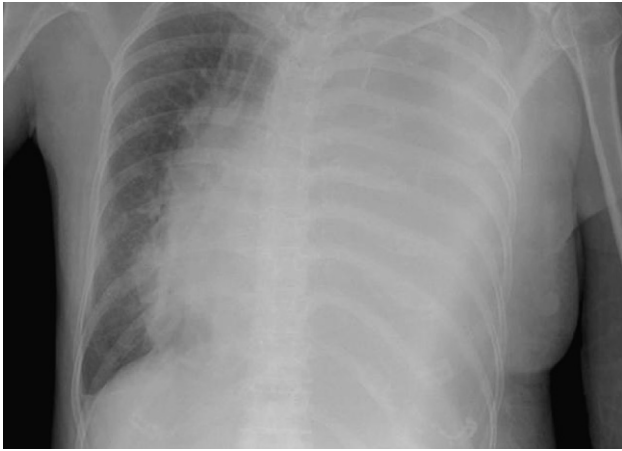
Posterior anterior chest X-ray obtained on the day of admission showing massive pleural effusion at the left side, with a shift of the heart and mediastinum to the right side.
